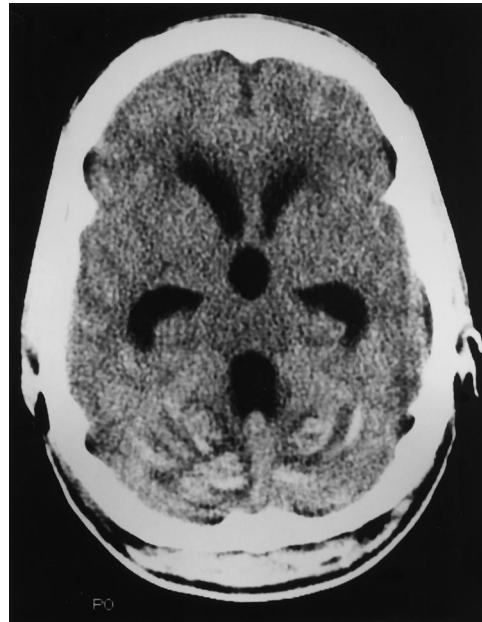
Axial CT shows ventricular enlargement and hemorrhagic cerebellar infarction.
